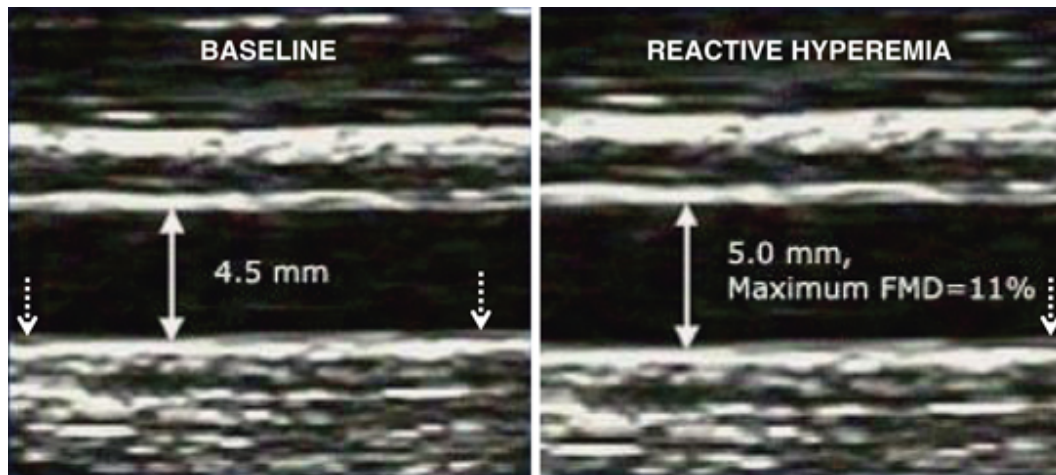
Ultrasound image of brachial artery before and after reactive hyperemia reproduced from: http://www.nature.com/ijir/journal/v22/n2/fig_tab/ijir200959f3.html
